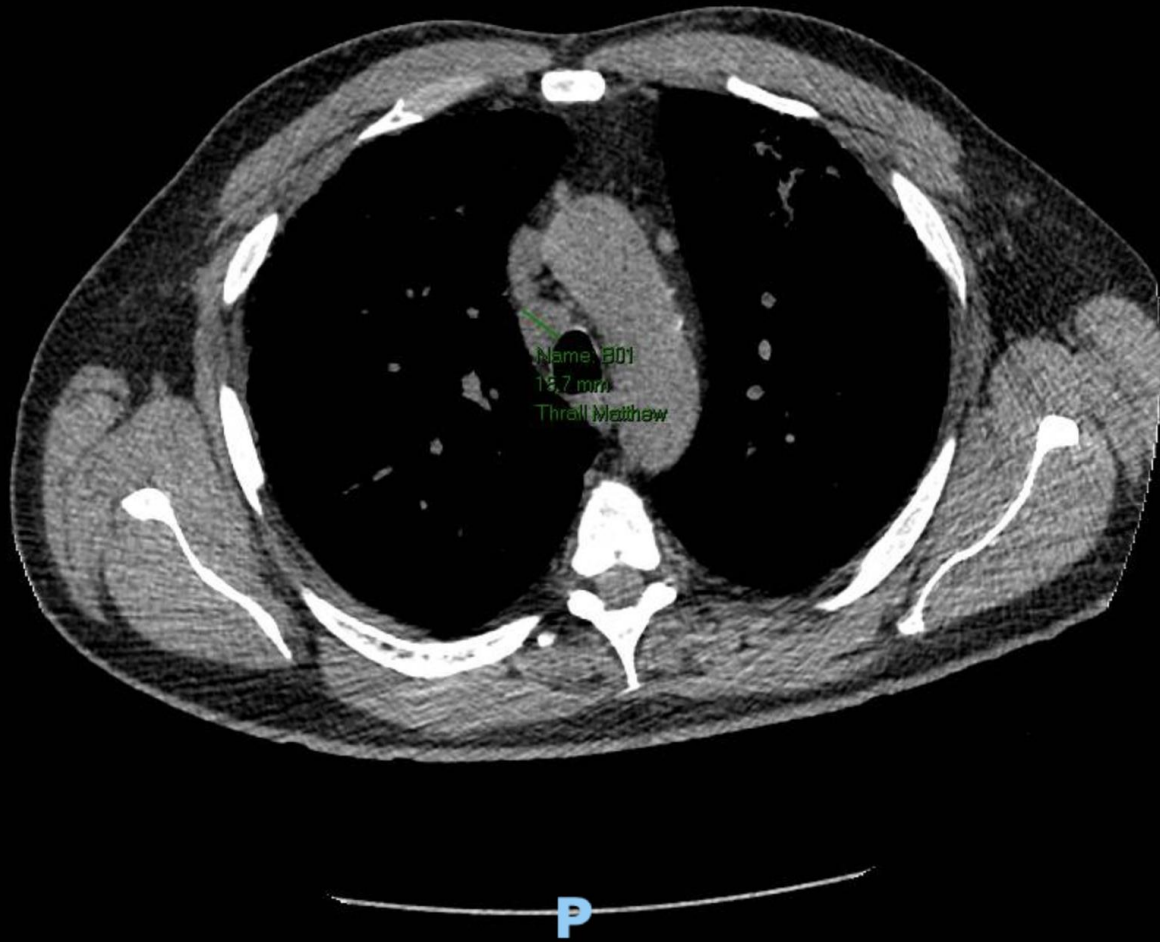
Low-dose CT scan (LDCT).
